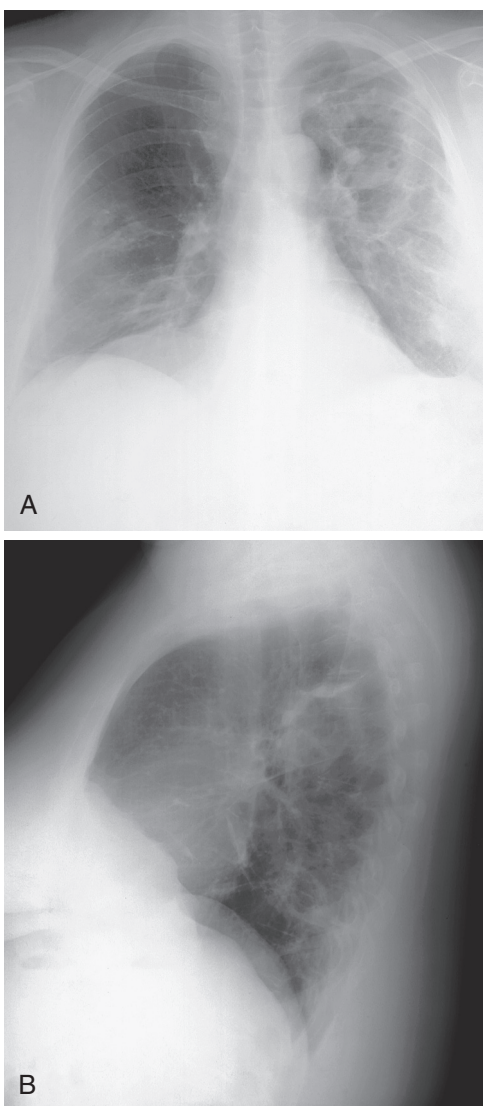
■ Posteroanterior (A) and lateral (B) chest radiographs demonstrating diffuse infiltrates with cavitation, radiographic features of *Legionella* infection.
